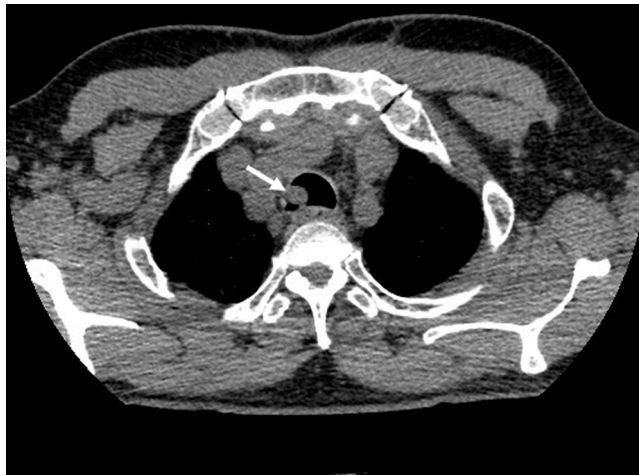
Chest computed tomography scan without contrast showing polypoid endoluminal lesion in the proximal right trachea (arrow).
